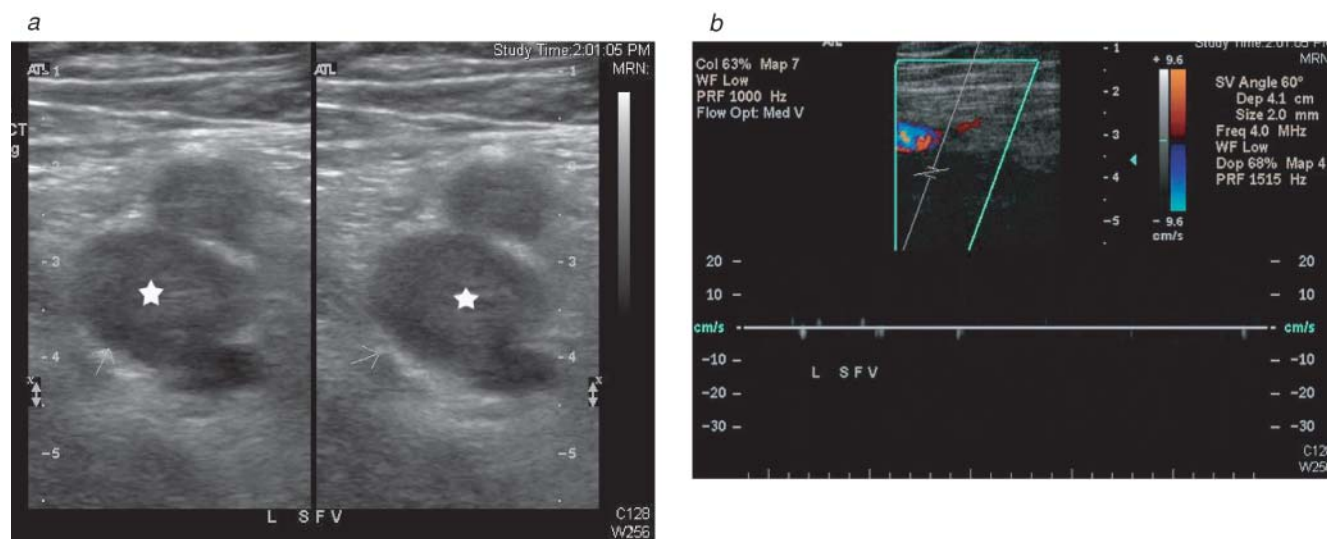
A 46-year-old male presented with left lower limb swelling and tenderness. (a) An ultrasound of the deep venous system of the left leg demonstrates echogenic material within the left superficial femoral vein (LSFV) (white star). There is noncompressibility of the LSFV (right panel). (b) On a color duplex ultrasound, there is no venous flow within the LSFV consistent with occlusive deep venous thrombus.
